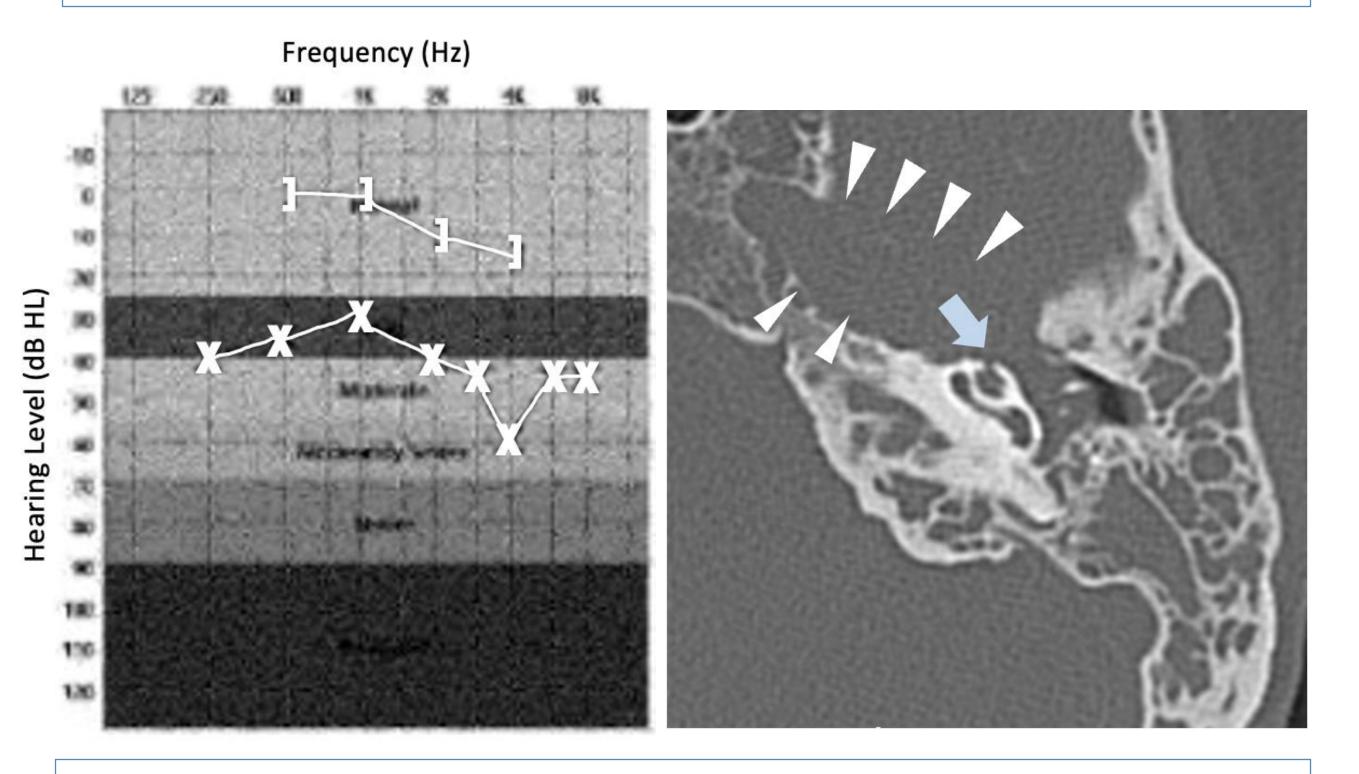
Left) Audiogram of left ear. Tympanometry and WRS not shown; Right) CT Temporal Bone w/o IV contrast showing expansile lesion in petrous carotid canal (white arrows) and focal dehiscence of the apical turn of the cochlea (blue arrow).
